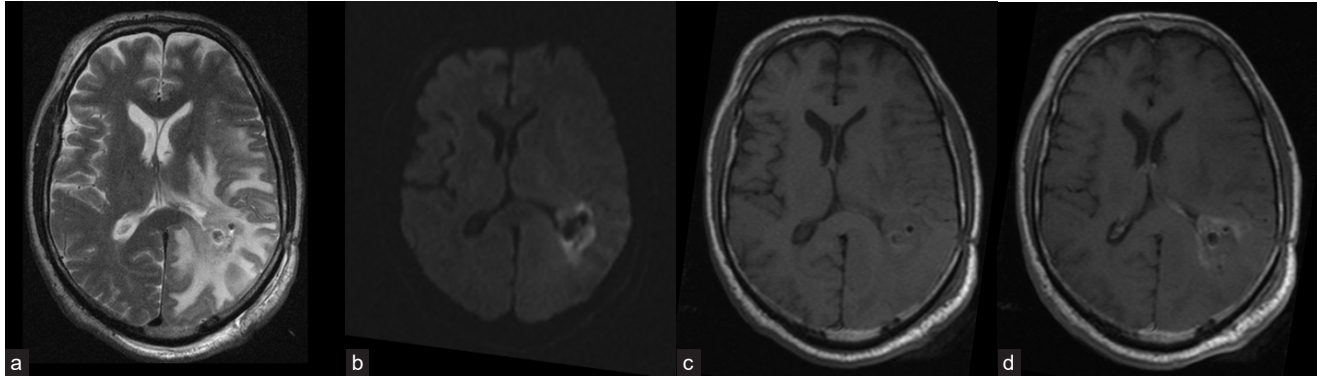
Contrast-enhanced MRI of the brain after sPDT: (a) T2-increase of perifocal edema area; (b) DWI (b 1,000) – diffusion restriction in the intervention area; (c) T1, before contrast - slight increase of signal intensity in the intervention area; and (d) post-contrast T1 – decrease of contrast agent accumulation in the intervention area.
